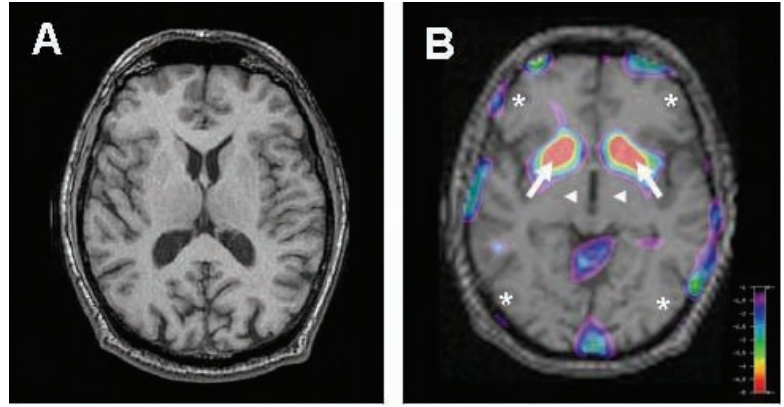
MRI and FDG-PET
